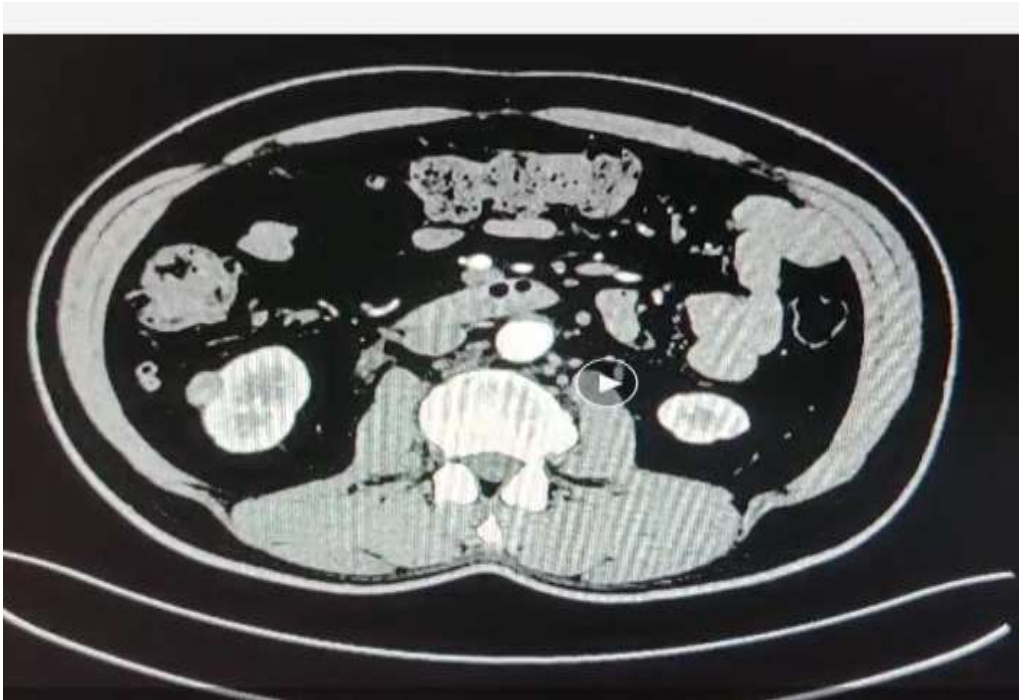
CT right kidney showing a renal tumor in the lower pole
